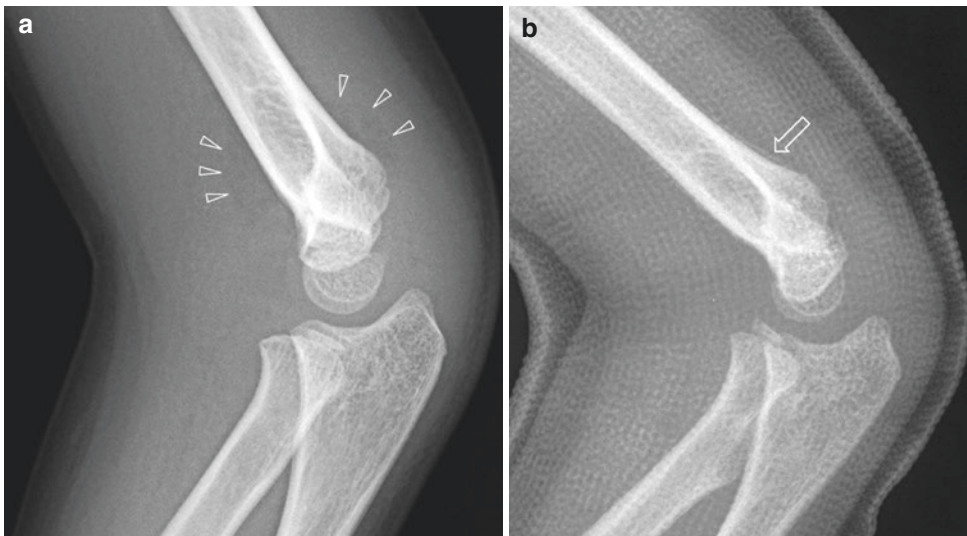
A 6-year-old boy who presented with pain in the left elbow after a fall onto his outstretched left hand. (a) Lateral radiograph of the left elbow shows no displaced fracture. The joint alignment is maintained. There is however a joint effusion, as indicated by elevated anterior and posterior fat pads (*arrowheads*). This finding should raise
